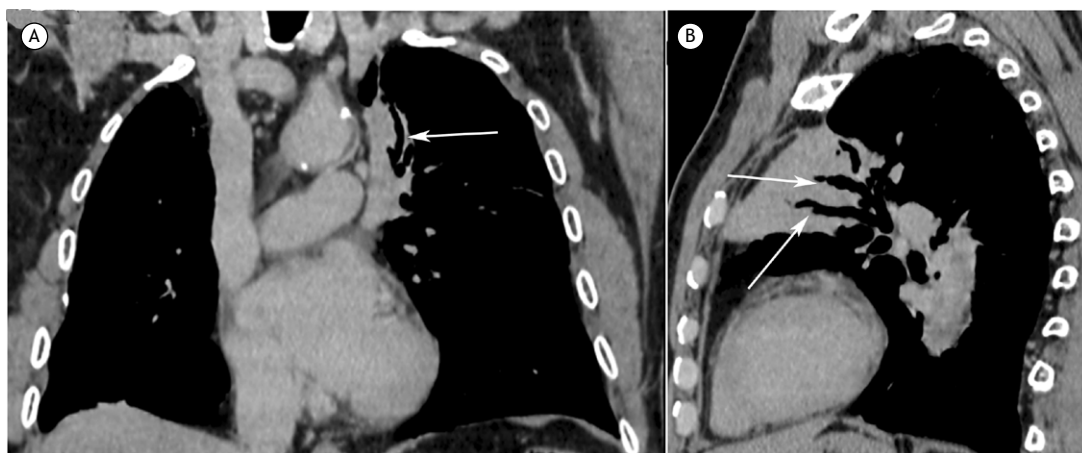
A 72-year-old man with biopsy-proven bronchus-associated lymphoid tissue lymphoma. Coronally (in A) and sagittally (in B) reconstructed CT images obtained with the mediastinal window setting showing an area of consolidation in the left upper lobe containing markedly dilated bronchi (arrows).
